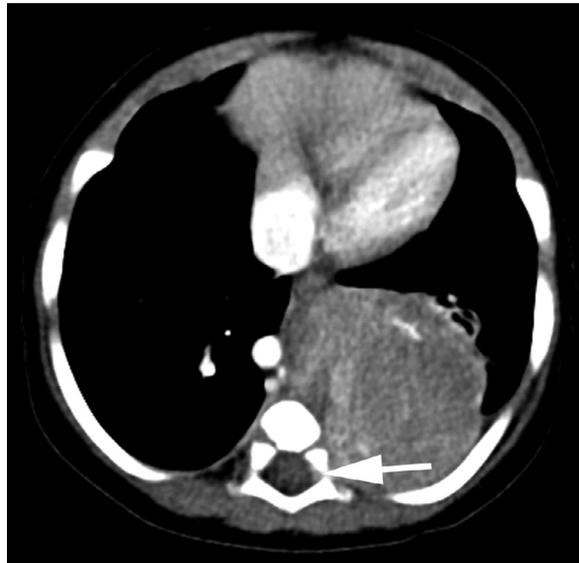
Noninvasion of the spinal canal but involvement of T9-T12 consistent with the presence of an IDRF (L2). Contrast-enhanced CT of a 6-month-old boy with a left side mediastinal tumor. There is enhancing tissue inside the left portion of the spinal canal (arrow), involving less than one-third of the area of the canal in that axial level. However, because the tumor involves the costovertebral junction between T9 and T12, it is consistent with an IDRF.
